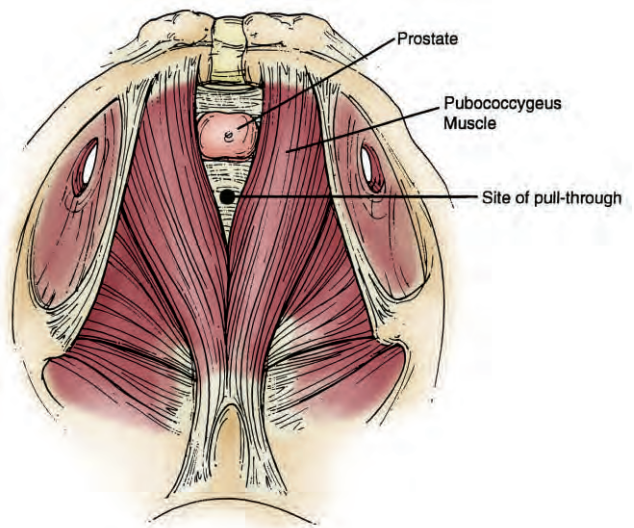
Laparoscopic visualization of the pelvis after dissection of the rectum out of the pelvis in a typical boy with high imperforate anus and rectourethral fistula. (From Georgeson KE, Inge TH, Albanese CT: Laparoscopically assisted anorectal pull-through for high imperforate anus: A new technique. *J Pediatr Surg* 35:927-931, 2000.)
